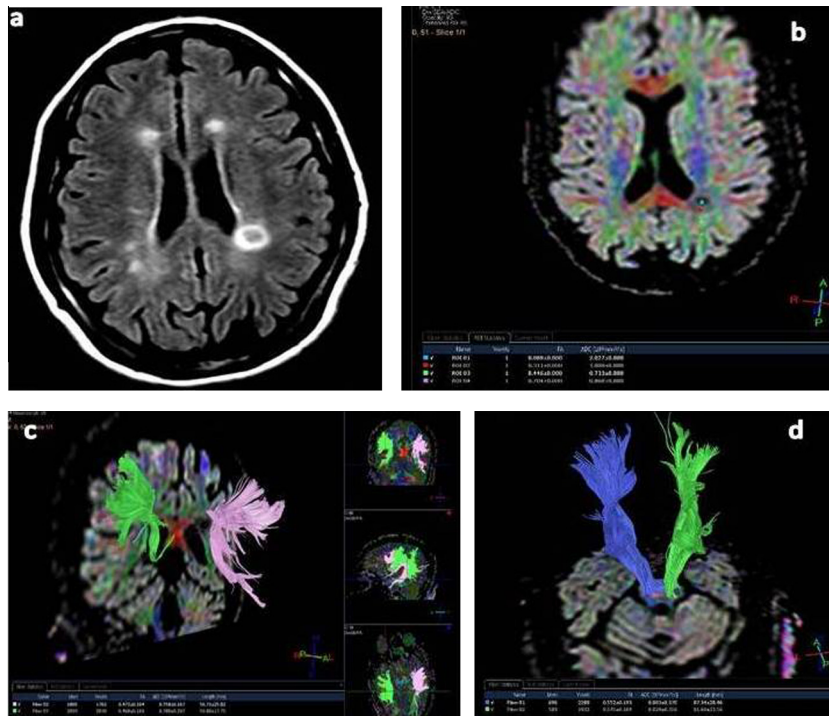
Images in 35 years old female RRMS patient; (a) axial view FLAIR MRI (9000/90/2000; matrix, 288×288 ; FOV, 230×230 mm; section thickness, 5 mm) shows bilateral peri-ventricular WM lesions (the largest one on left side shows black holes). Suggestive of multifocal white matter disease. (b) ROIs for the evaluation of tracts in MS white matter lesions. (c and d) Fiber tractography; shows reduced number of fibers when they traverse white matter lesions and cross-sectional area of the CST (green) on the affected side (FA at fibers measures 0.43 while MD 0.90).
